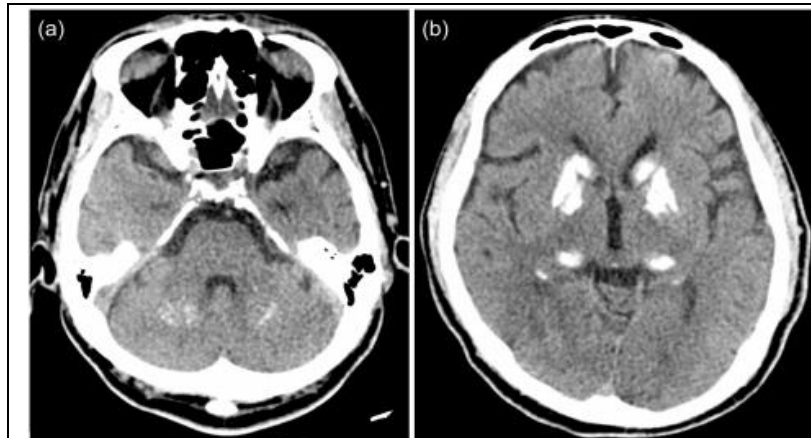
A brain computed tomography image demonstrating bilateral calcification of the dentate nucleus, thalamus, and basal ganglia.
